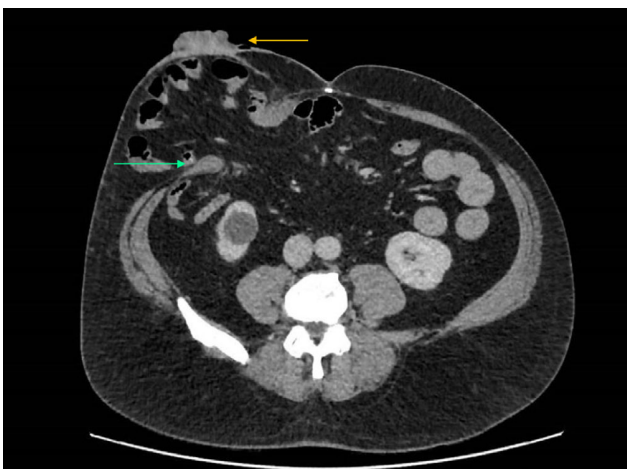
Axial phase CT scan demonstrating superficial soft tissue lesion at end ileostomy site (yellow arrow) and a non-obstructed parastomal hernia with a wide neck (green arrow).
